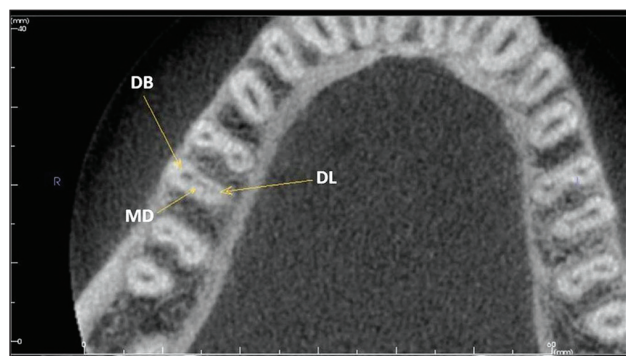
Cone beam computed tomography scan view at the middle third showing three distinct root canals; distobuccal; middle distal; distolingual
